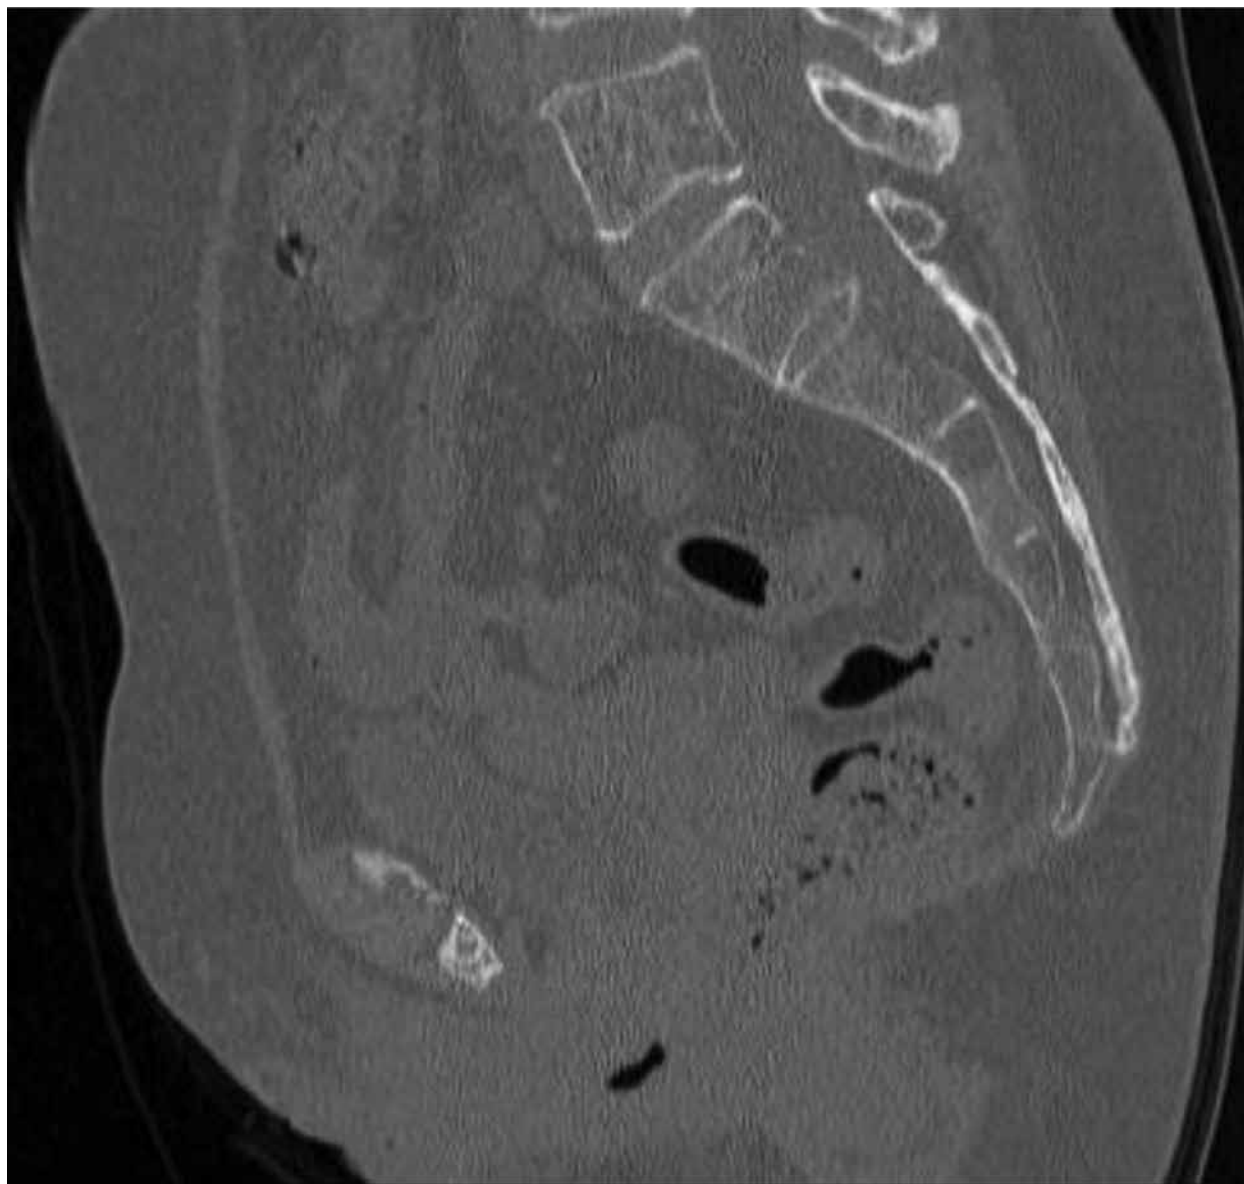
CT Pelvis. Sagittal view. Surgical absence of the coccygeal segments. The sacrum appears unremarkable with normal alignment of the sacral segments. The lower lumbar spine appears normal with no features of spondylolysis or spondylolisthesis, and the neural foramina appear well-maintained. Within the lower pelvis at the site of the coccygeal resection, there is no abnormal residual soft tissue mass or fluid collection. The presacral space appears well maintained. There are no abnormal calcifications identified.
